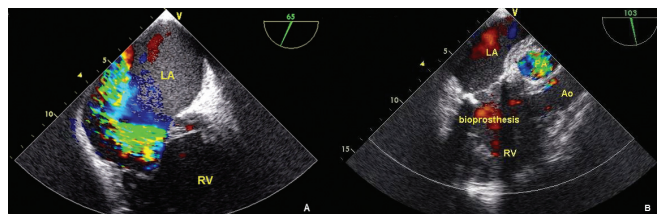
A, Preoperative midesophageal echocardiogram. B, Intraoperative midesophageal 3-chamber echocardiogram. LA, left atrium; RV, right ventricle (morphologic left ventricle); Ao, aorta; PA, pulmonary artery.
